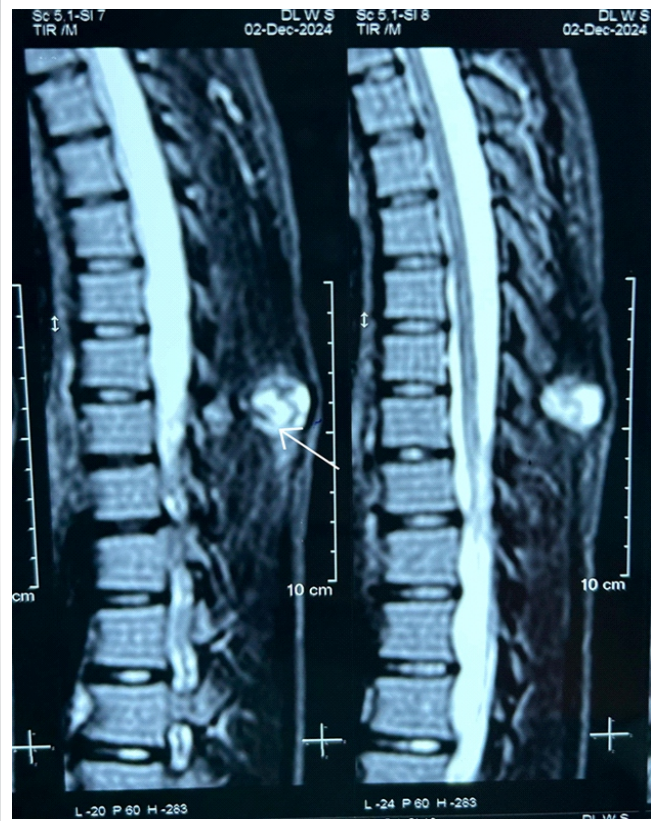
Magnetic resonance imaging film (T2-weighted sagittal image) shows a well-defined, lobulated mass which is hypointense at the periphery with central hyperintensity arising from the posterior element of D8 vertebra. (marked with arrow).
